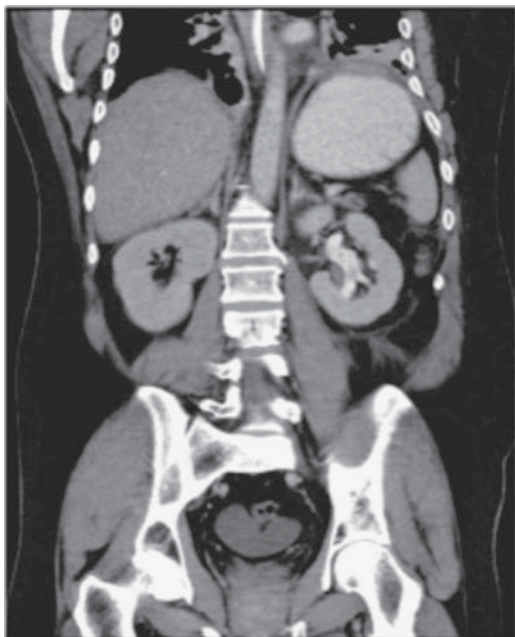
Coronal reformatted CT image. This shows the left kidney has mild distension of the pelvicalyceal system and has retained excreted contrast medium. The right kidney has cleared of contrast medium. One of the typical features of an obstructed system is delayed excretion and persistence of the enhancement. Note that acutely obstructed systems may not be very dilated.
